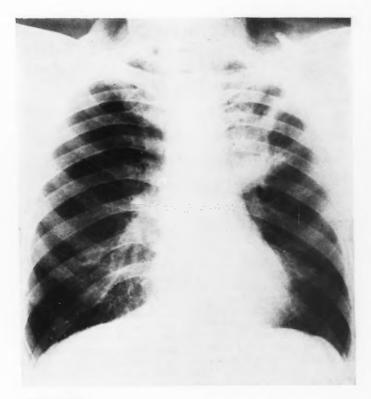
Six months later, this roentgenogram showed abnormality in the second interspace on the left. Since the patient was clinically well, he was not told of this defect, and it was read as insignificant.
